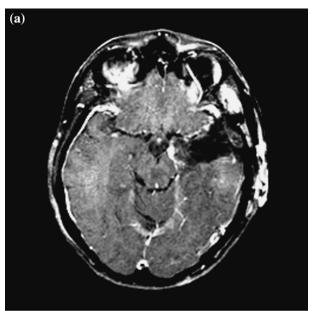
(a) Axial T1-weighted image after gadolinium administration. (b) Coronal T1-weighted image after gadolinium administration. These post-operative images demonstrate complete resection of the tumor.
